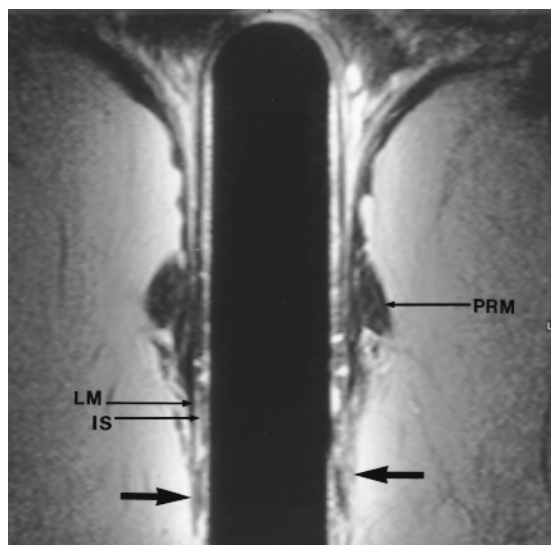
Coronal T2-weighted turbo spin-echo (2,500/100) MR image shows an atrophic external sphincter, only some thin portions of which remain (arrows) (cf Fig 2c). The internal sphincter (IS), longitudinal muscle (LM), and puborectal muscle (PRM) are normal.
